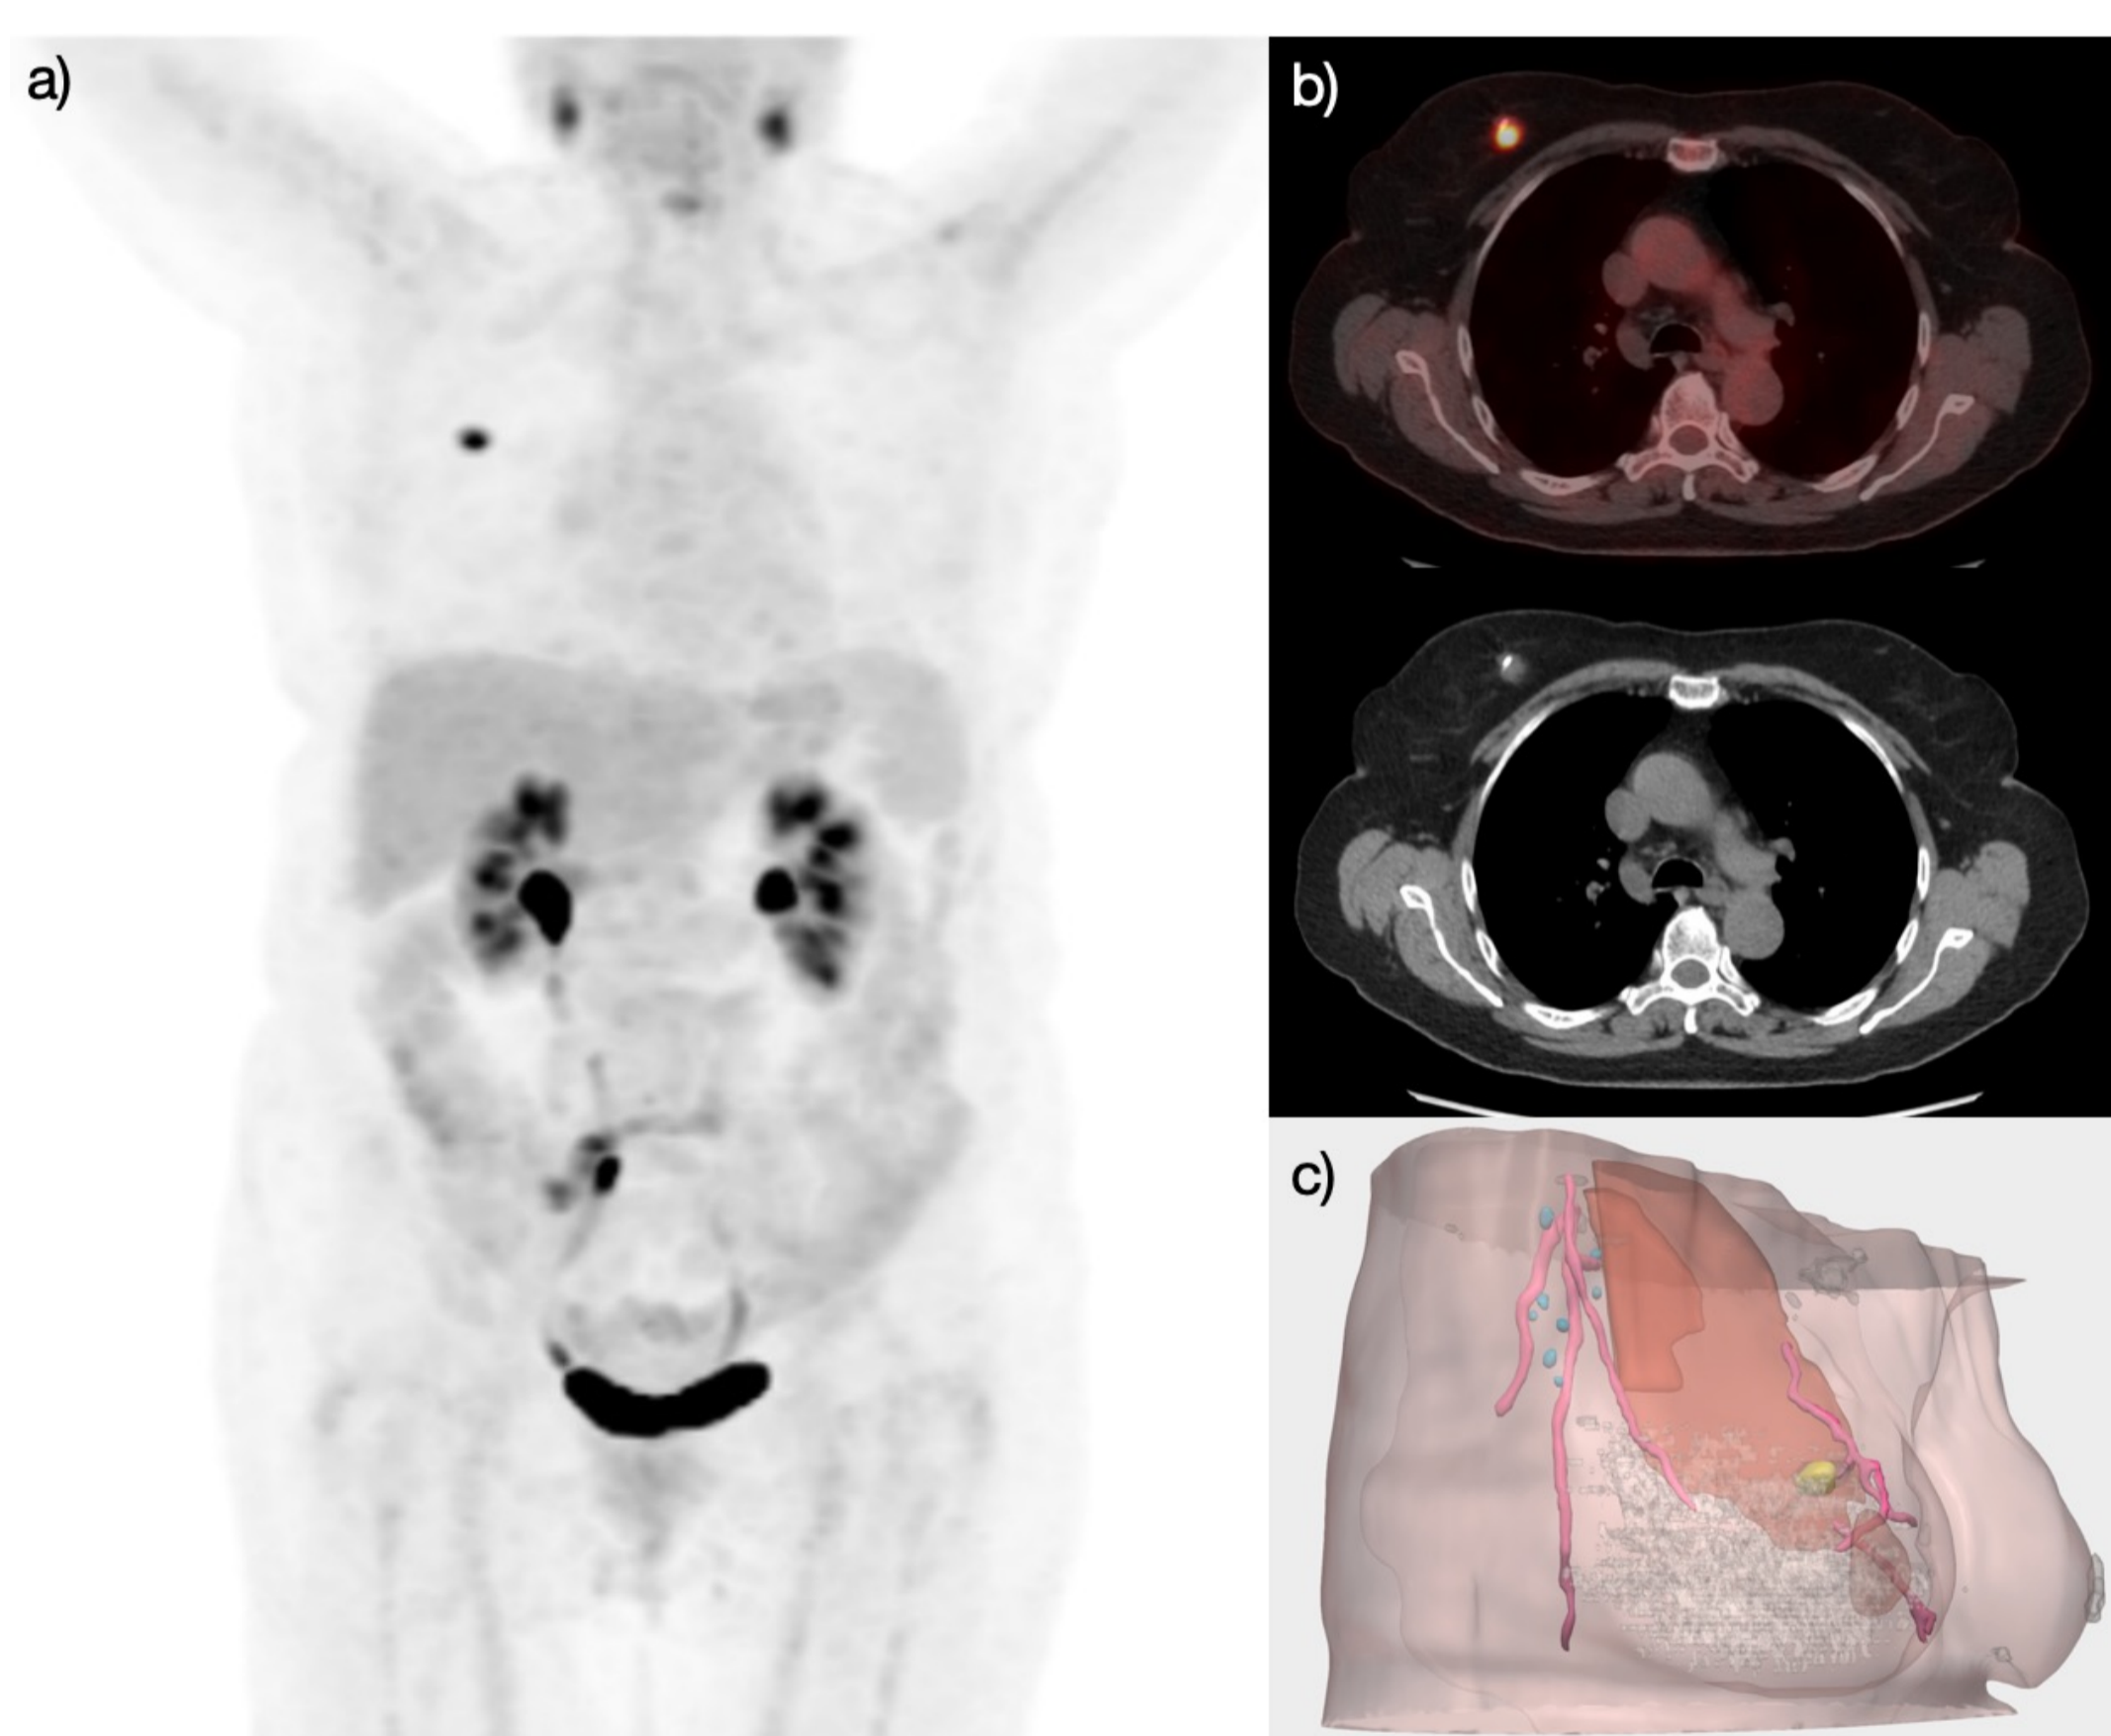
a) Whole-body PET image with MIP reconstruction showing a hypermetabolic nodular lesion in the right breast, corresponding to a triple-negative breast carcinoma. b) Axial PET-CT fusion image (top) showing a hypermetabolic lesion in the upper inner quadrant (UIQ) of the right breast, and CT scan (bottom) showing the morphological characteristics of the lesion, which includes a radiological marker (scout). c) AI-based segmentation with three-dimensional reconstruction from PET-CT, showing the tumor lesion and the different anatomical structures.
